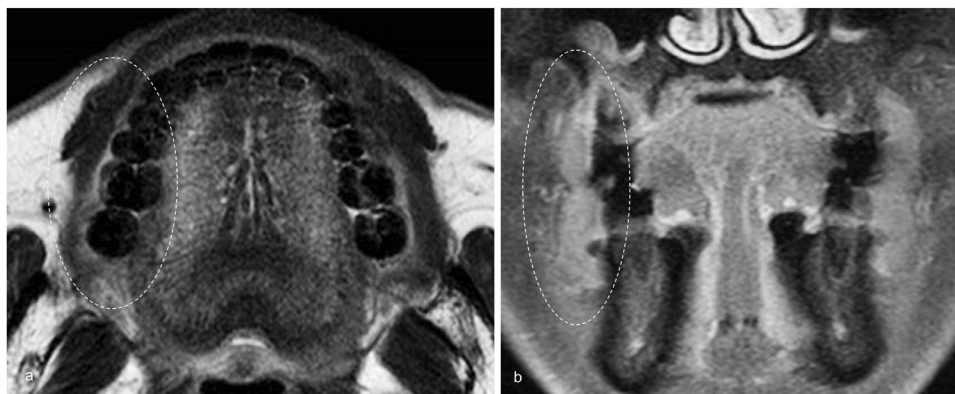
Undetectable lesion of squamous cell carcinoma of the buccal mucosa (SCCBM) on magnetic resonance imaging. A 70-year-old male with SCCBM on the right side. Neither the (a) axial T2-weighted image nor the (b) coronal contrast-enhanced fat-suppressed T1-weighted coronal image reveal the lesion in the right buccal mucosa (within dotted circle), in which SCCBM was proven clinically and pathologically.
